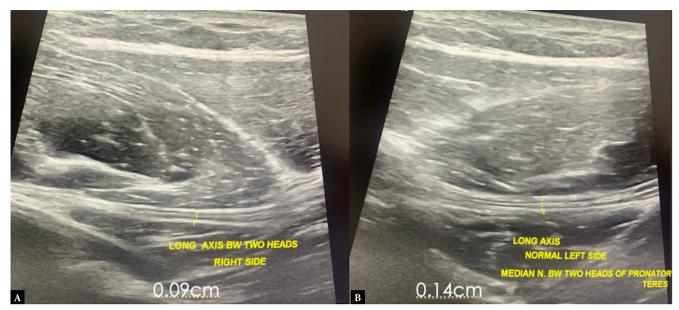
Longitudinal sonographic images showing compression of median nerve between the two heads of pronator teres on right (A), normal left (B)
